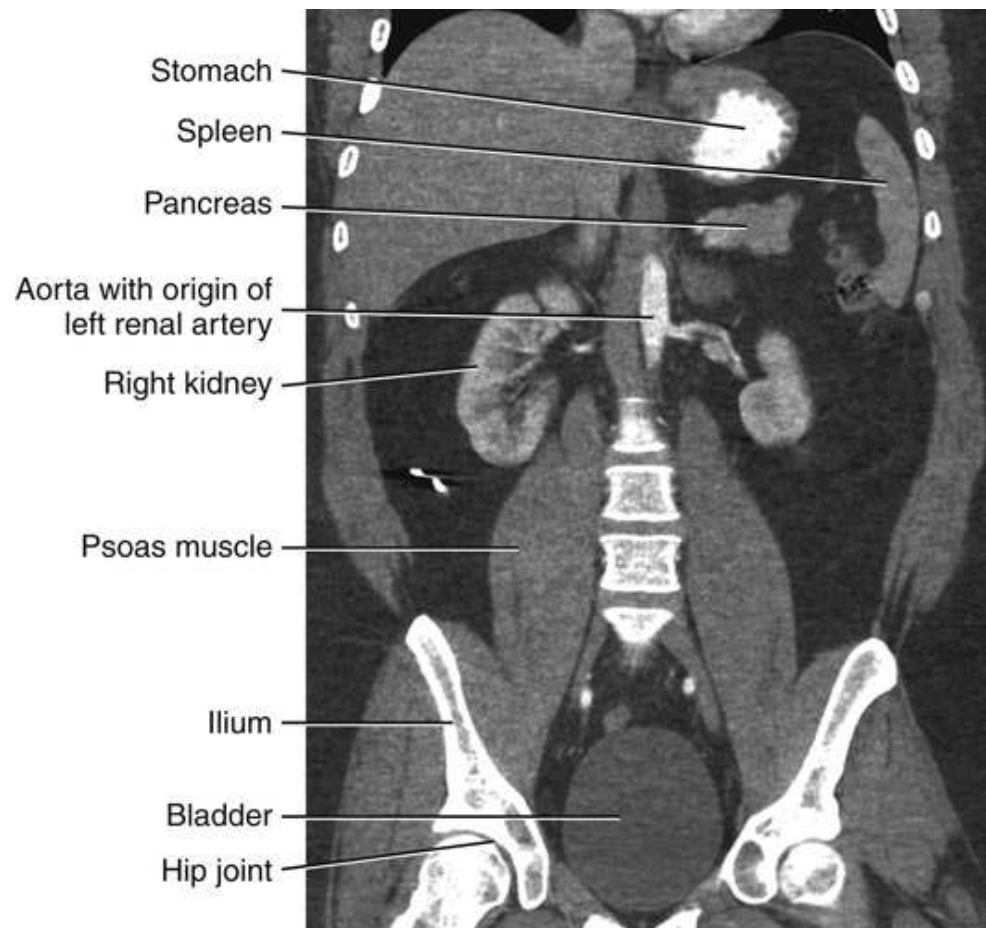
Coronal CT image of abdomen posterior to midcoronal plane.
